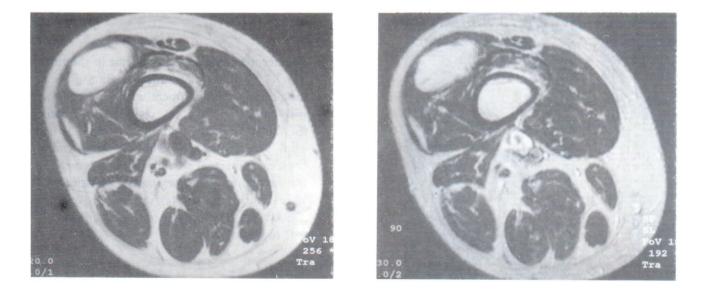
Intramuscular lipoma in the thigh in a 45 year old Chinese lady (a) Axial T1-weighted and (b) axial T2-weighted MR images shows a well-defined mass in the vastus lateralis. It displays high signal on both the T1-weighted and T2-weighted spin-echo sequences with signal characteristics similar to that of the subcutaneous fat. There are fine septae within it. The features are suggestive of a lipomatous lesion, most likely an intramuscular lipoma.
